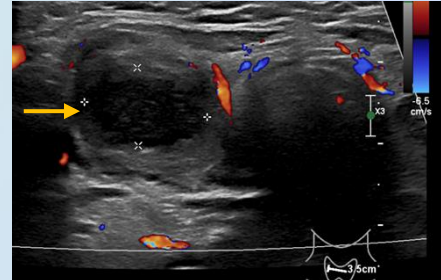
Ultrasound thyroid showed hypoechoic lesions with fine internal echoes (arrow).
